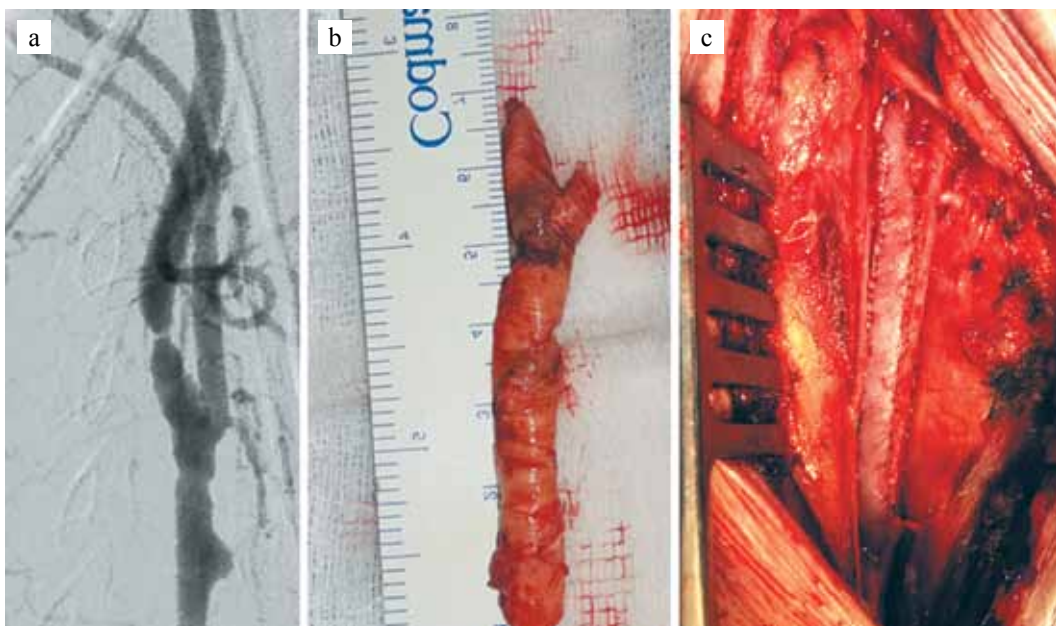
A clinical example of the presence of an extended atherosclerotic lesion: a) right carotid bifurcation CT angiography (90% ICA stenosis); b) removed atherosclerotic plaque, 7 cm long; c) diepoxide-treated xenopericardial implanted patch
